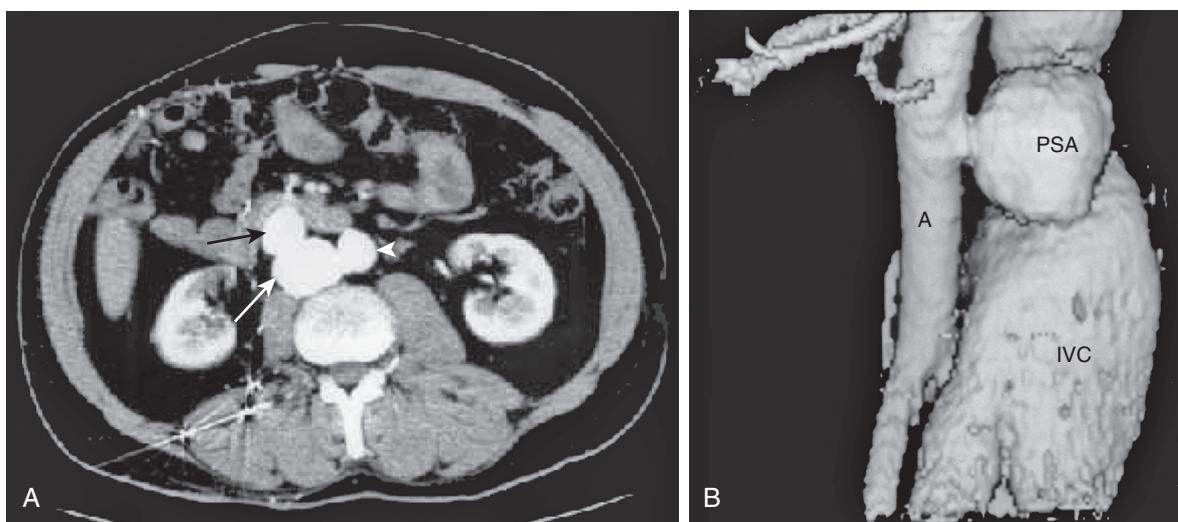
(A) Axial CT scan demonstrating the aorta (arrowhead), pseudoaneurysm (white arrow), and inferior vena cava (black arrow). (B) Three-dimensional reconstruction of the CT scan of a traumatic aortocaval fistula demonstrating a pseudoaneurysm (PSA), enlarged inferior vena cava (IVC), and aorta (A).
